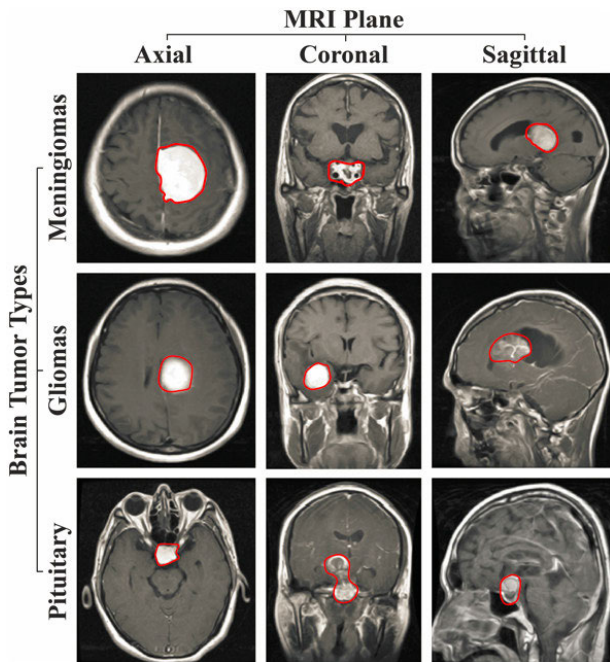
The representation of different tumor types in Brain MRI images.
